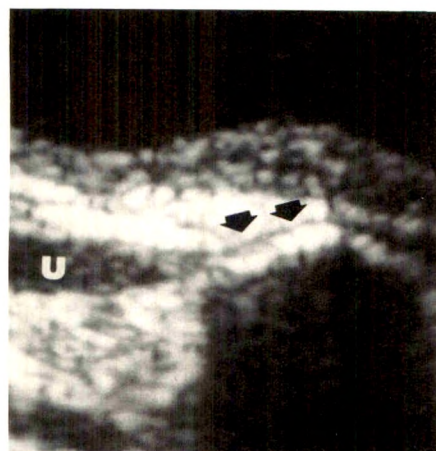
Longitudinal sonogram in 4-year-old girl shows distal portion of ureter (u) is lifted up and tapered by Teflon beneath (arrows). There is marked acoustic shadowing.
